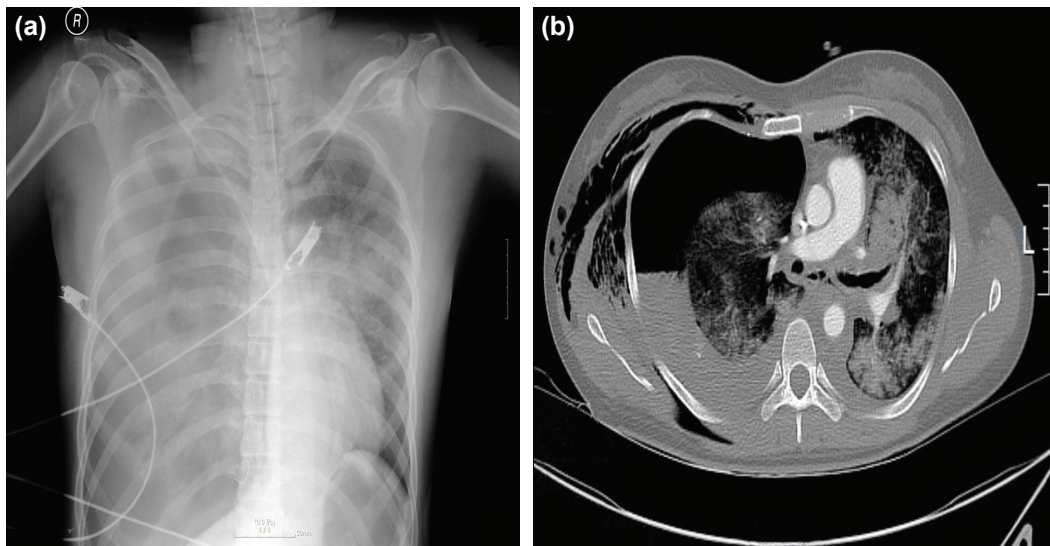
Simple chest radiography (a) and chest computed tomography (b) show a large right hemopneumothorax and severe contusion of the left lung.
